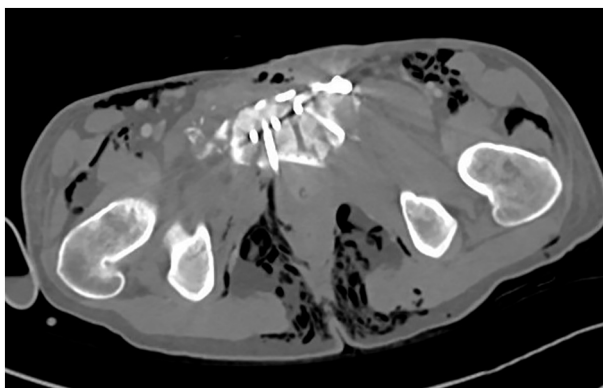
Axial CT cut, showing subcutaneous gas in pelvic region.
